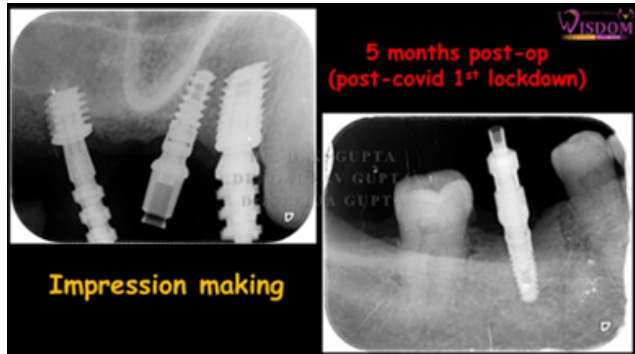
Radiograph depicting closed tray impression making.
